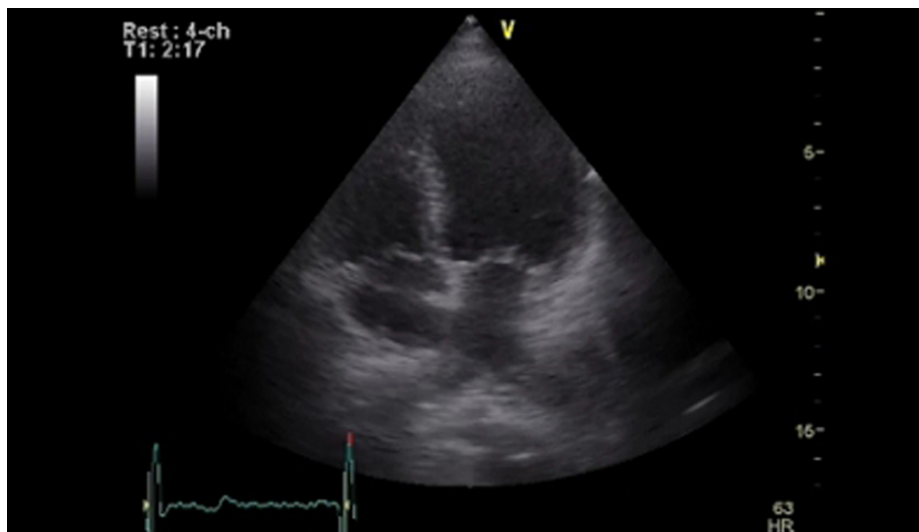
Resting echocardiogram, LVED volume: 69.40 ml, IVS: 1.25 cm, LVIDd (left ventricular internal dimension at diastole): 3.99 cm, LVIDs (left ventricular internal dimension at systole): 2.64 cm, ESV: 25.61, EF: 63.09%, SV: 43.78 ml.
